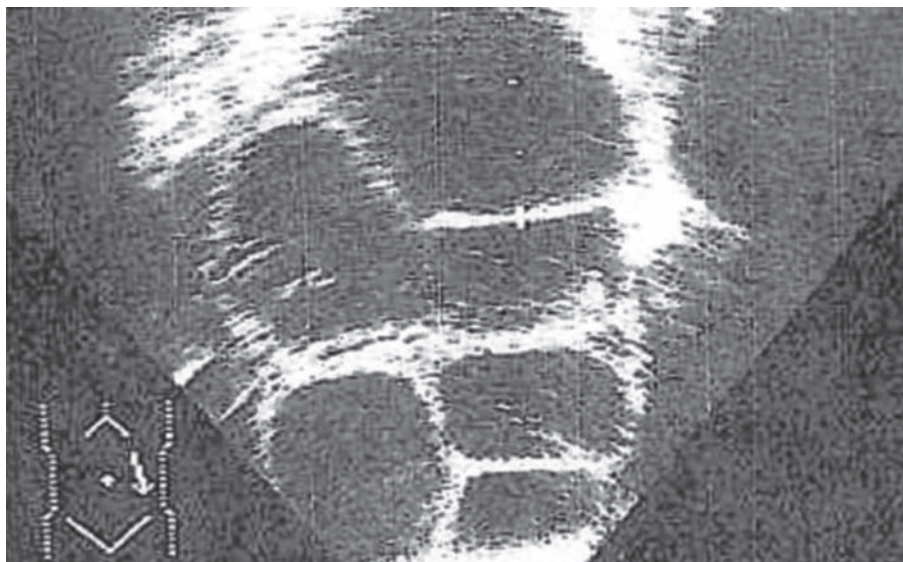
Ultrasound of hyperstimulation syndrome
